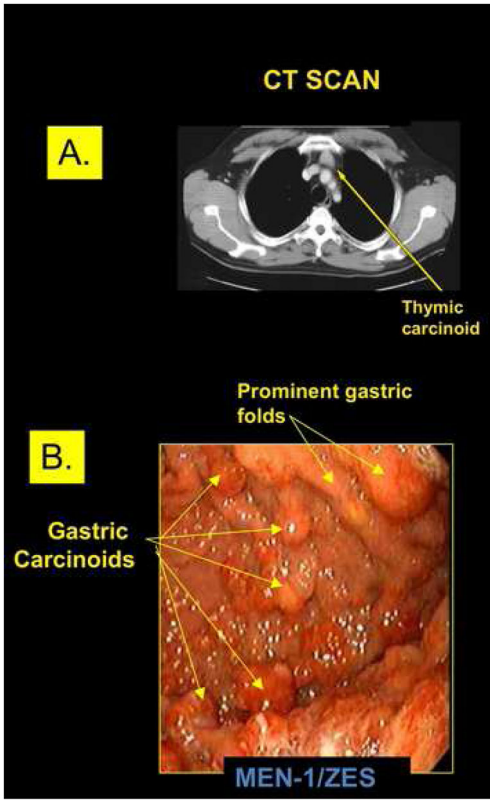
(A) Thymic carcinoid on CT, (B) type 2 gastric carcinoids on endoscopy
